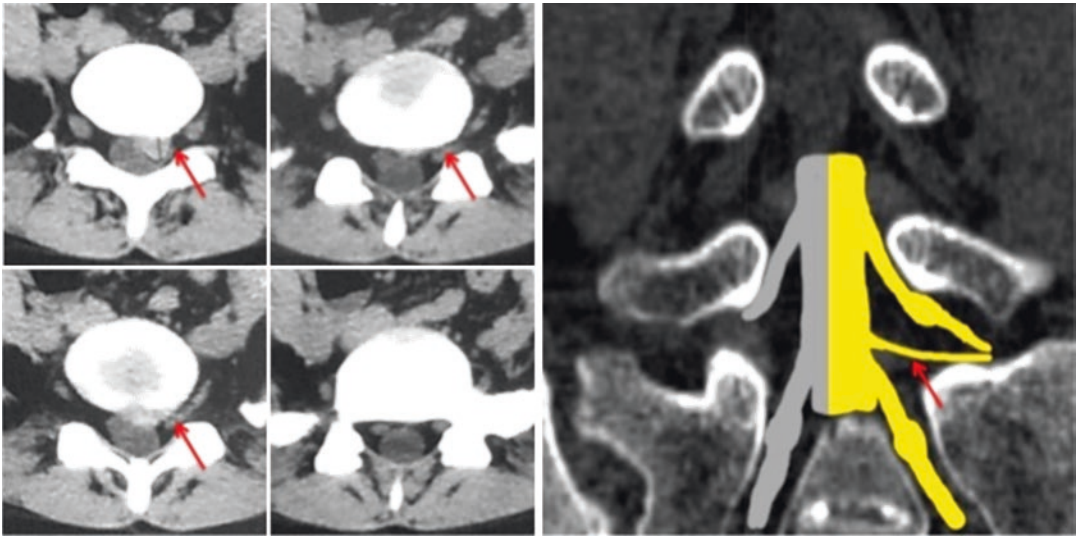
Type 2B anomaly of nerve root confirmed on preoperative CT scan (red arrows)
